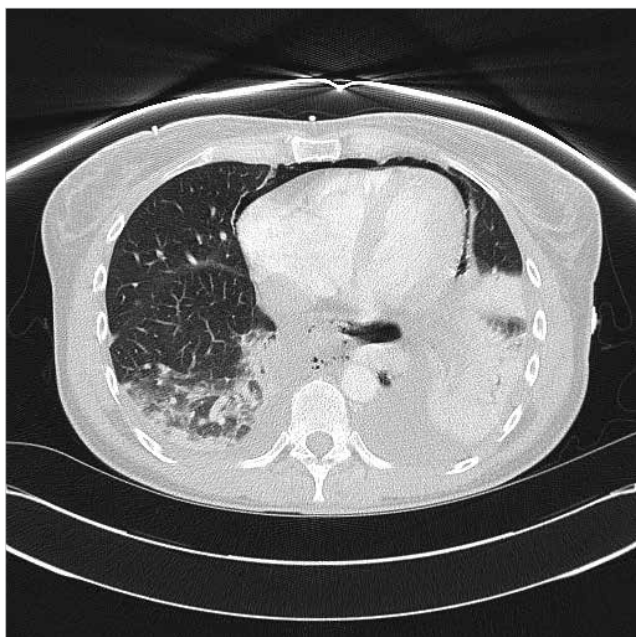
CT showing free air in the mediastinum lateral to the esophagus.
